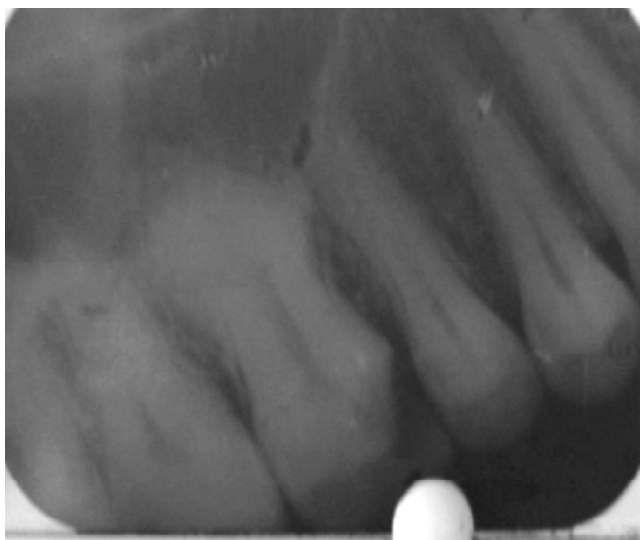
Pre-operative radiograph of the maxillary right first molar
